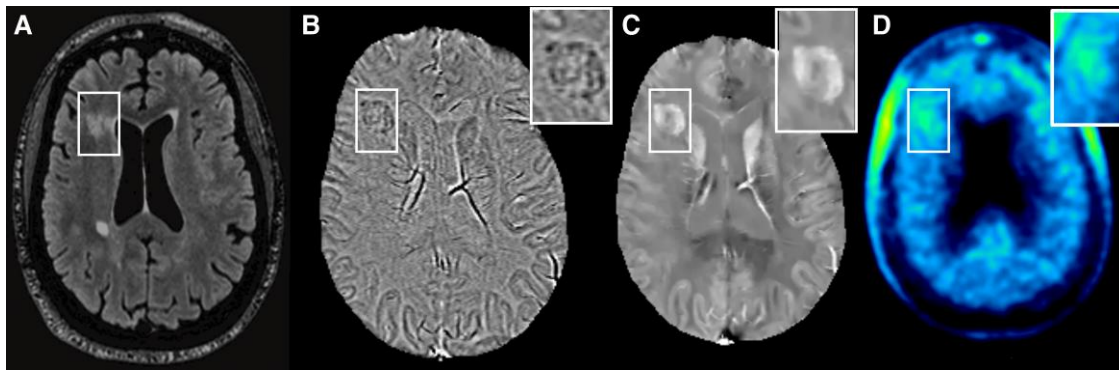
Increased uptake of 18-kDa translocator protein (TSPO) on PK11195 PET in a paramagnetic rim lesion. (A) Hyperintense lesion on T₂-weighted FLAIR image identified within the rectangle in a person with relapsing-remitting multiple sclerosis. The lesion is a paramagnetic rim lesion (PRL), as seen on the unwrapped filtered phase image (B, inset) and quantitative susceptibility map (C, inset). It has corresponding high TSPO uptake on PK11195-PET (D, inset). Image contributed by Dr Ulrike Kaunzner, Dr Thanh Nguyen and Dr Yeona Kang. FLAIR = fluid attenuated inversion recovery.
